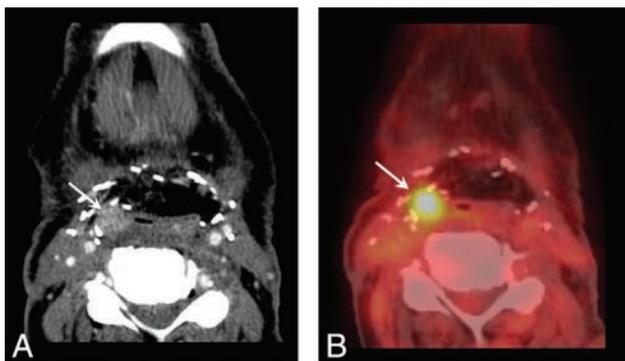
NI-RADS primary site category 3: discrete enhancing lesion. T4a larynx squamous cell carcinoma, status post total laryngectomy, bilateral neck dissection, and chemoradiotherapy. *A*, CECT shows a 1-cm discrete rounded hyperenhancing nodule along the lateral border of neopharynx, deep to the flap (*arrow*). *B*, Fused PET images show focal high FDG uptake (*arrow*). This was given a category 3 score, and endoscopic biopsy demonstrated recurrence.
